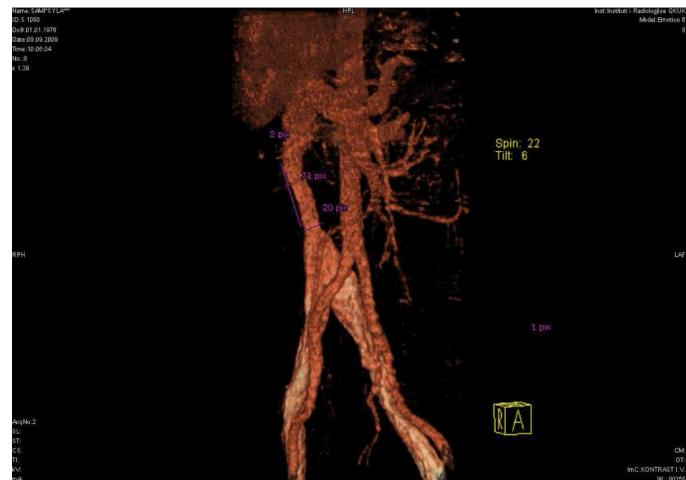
Angio computed tomography and measures of the graft.
